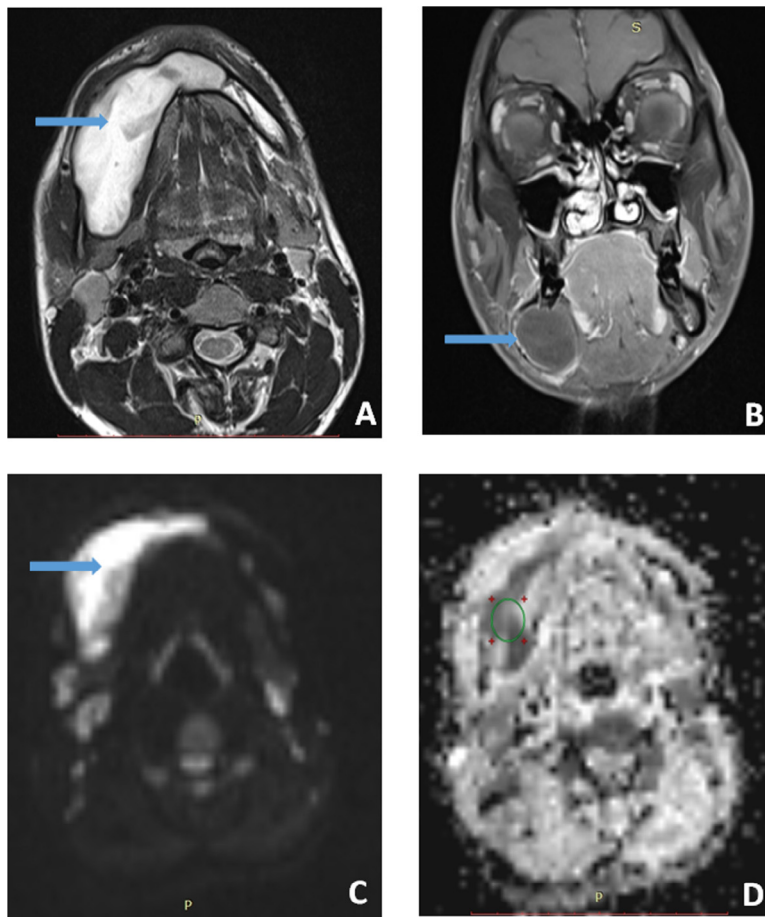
A–D, An 18-year-old male patient with odontogenic keratocyst (OKC). Axial T2-weighted image (A) shows a well-defined hyperintense lesion (*blue arrow*) involving the body of the right mandible extending to the midline. Postcontrast coronal T1-weighted image (B) shows thin peripheral rim enhancement of the lesion. Axial diffusion-weighted imaging (DWI) scan at $b\text{-value} = 800 \text{ s/mm}^2$ (C) reveals high signal intensity of the lesion (*blue arrow*) with a corresponding apparent diffusion coefficient (ADC) map (D) showing loss of signal suggestive of restricted diffusion (*green circle*). Mean ADC value of the lesion is $0.827 \times 10^{-3} \text{ mm}^2/\text{s}$.
